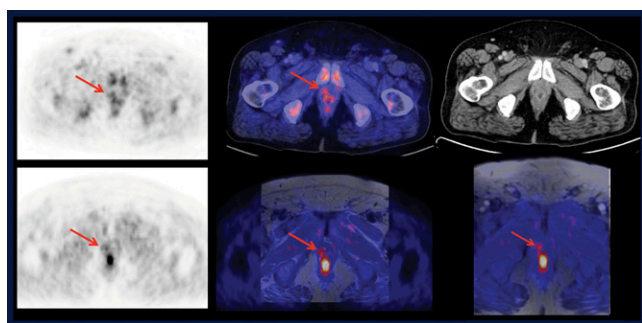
Comparison of PET/CT and PET/MR in local recurrence of prostate cancer. Top row: PET alone from PET/CT shows a very faint uptake of choline in the former prostate fossa with no additional information provided by fusion (middle) with contrast-enhanced CT (right). Bottom row: In the subsequent PET from PET/MR a faint uptake was seen in the same position. Fusion (middle) with high-resolution T2-weighted images showed that this uptake was not retained urine in the urethra but was located in the soft tissue. The addition of dynamic contrast-enhanced MR imaging (right) showed an arterial hypervascularized lesion in the same region.
